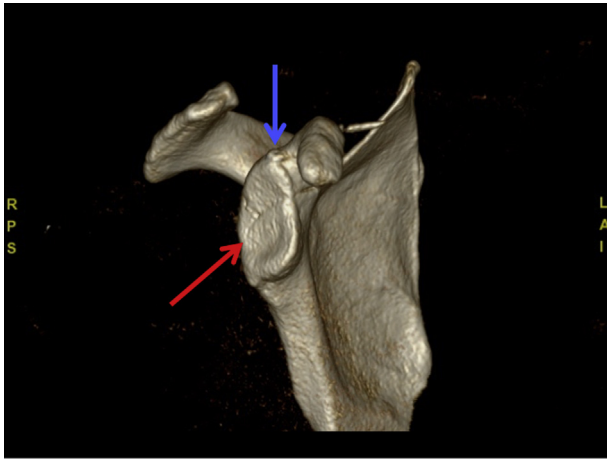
Computed tomography of the right shoulder with 3-dimensional reconstruction and subtraction of the humerus 2 days postoperatively after screw osteosynthesis of the displaced transverse glenoid fracture (Ideberg type III). Fracture reduction is excellent, displaying no step of the joint surface. The red arrow marks the fracture line. The blue arrow marks the head of the cannulated screw.
